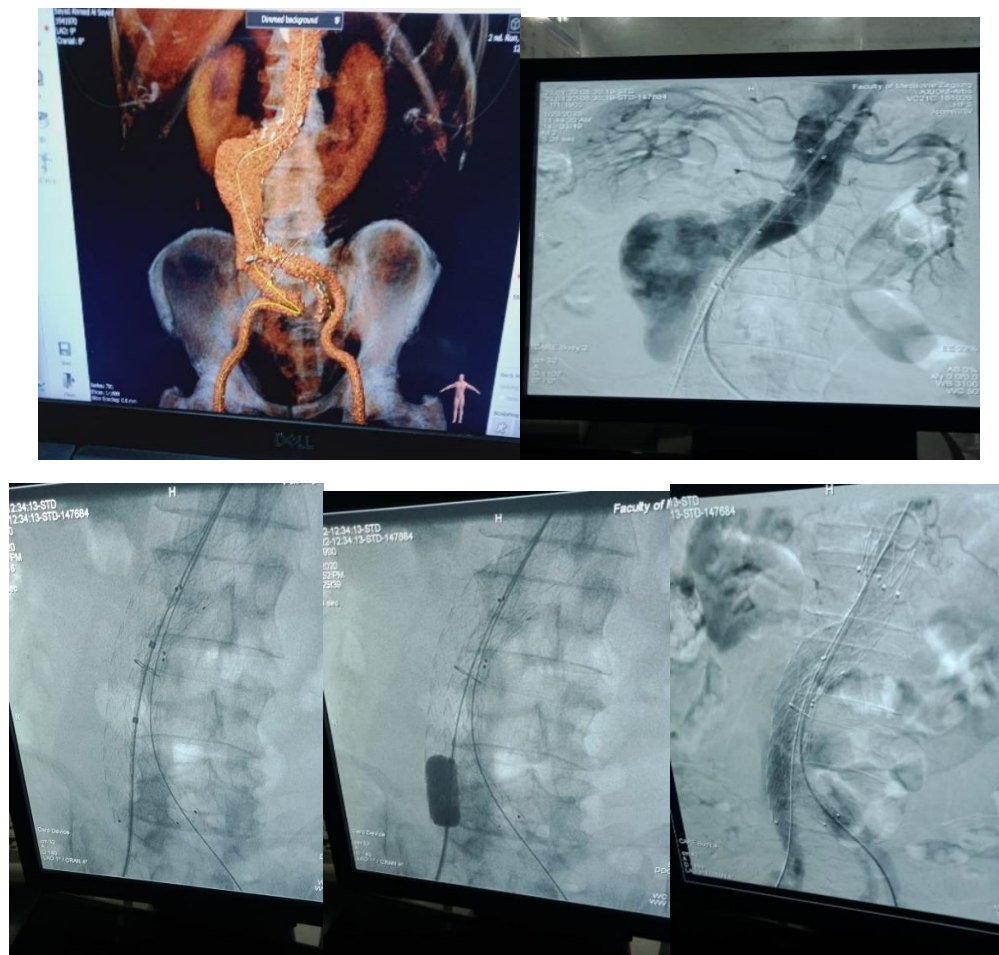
A case of EVAR. (a): preoperative CTA. (b): aortogram for accurate positioning of main body below lower renal artery. (c): after deployment of main body and contralateral limb. (d): balloon dilatation of distal end for better sealing. (e): completion aortogram with no endoleak.
